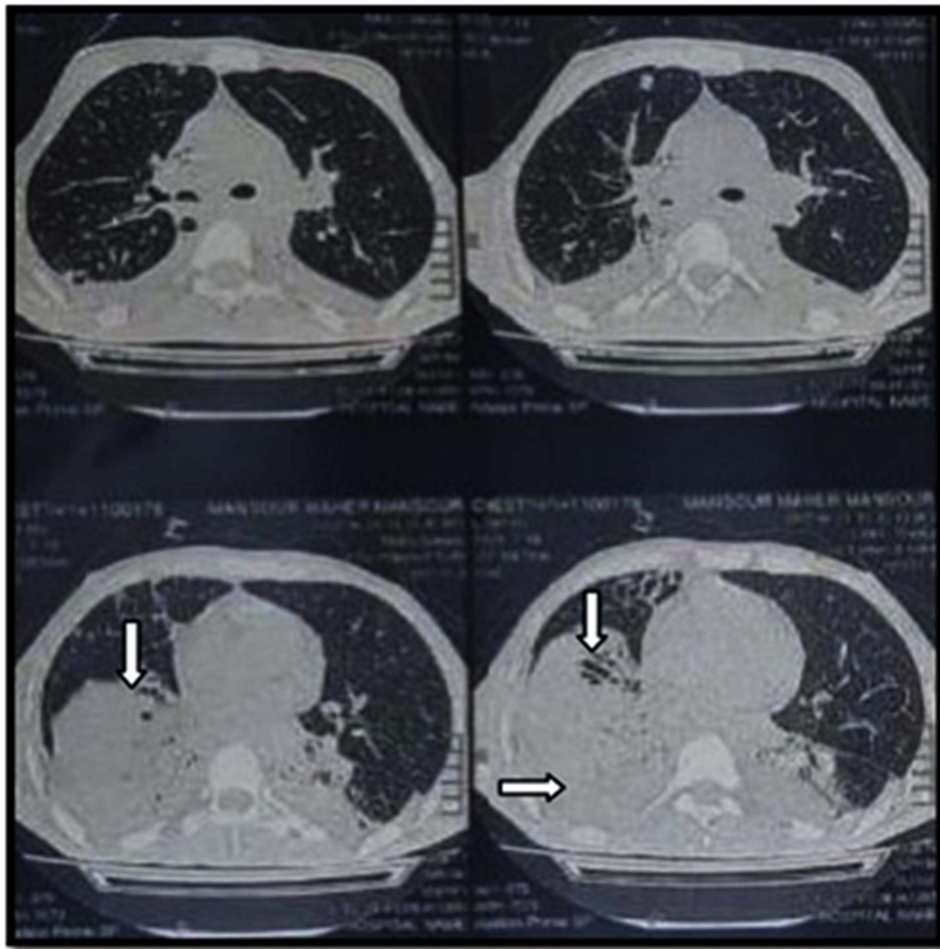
Chest computed tomography (CT). The arrows point to consolidation areas with air bronchogram and effusion.
